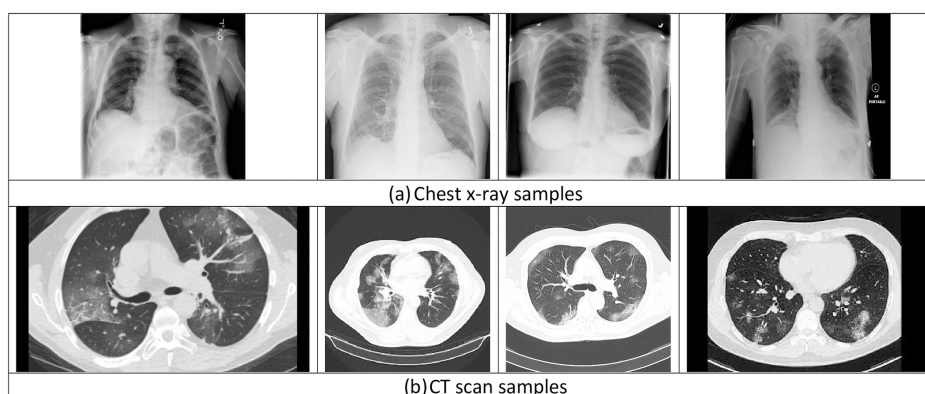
Sample of the two datasets: (a) chest X-ray images; (b) CT scans. [14]
